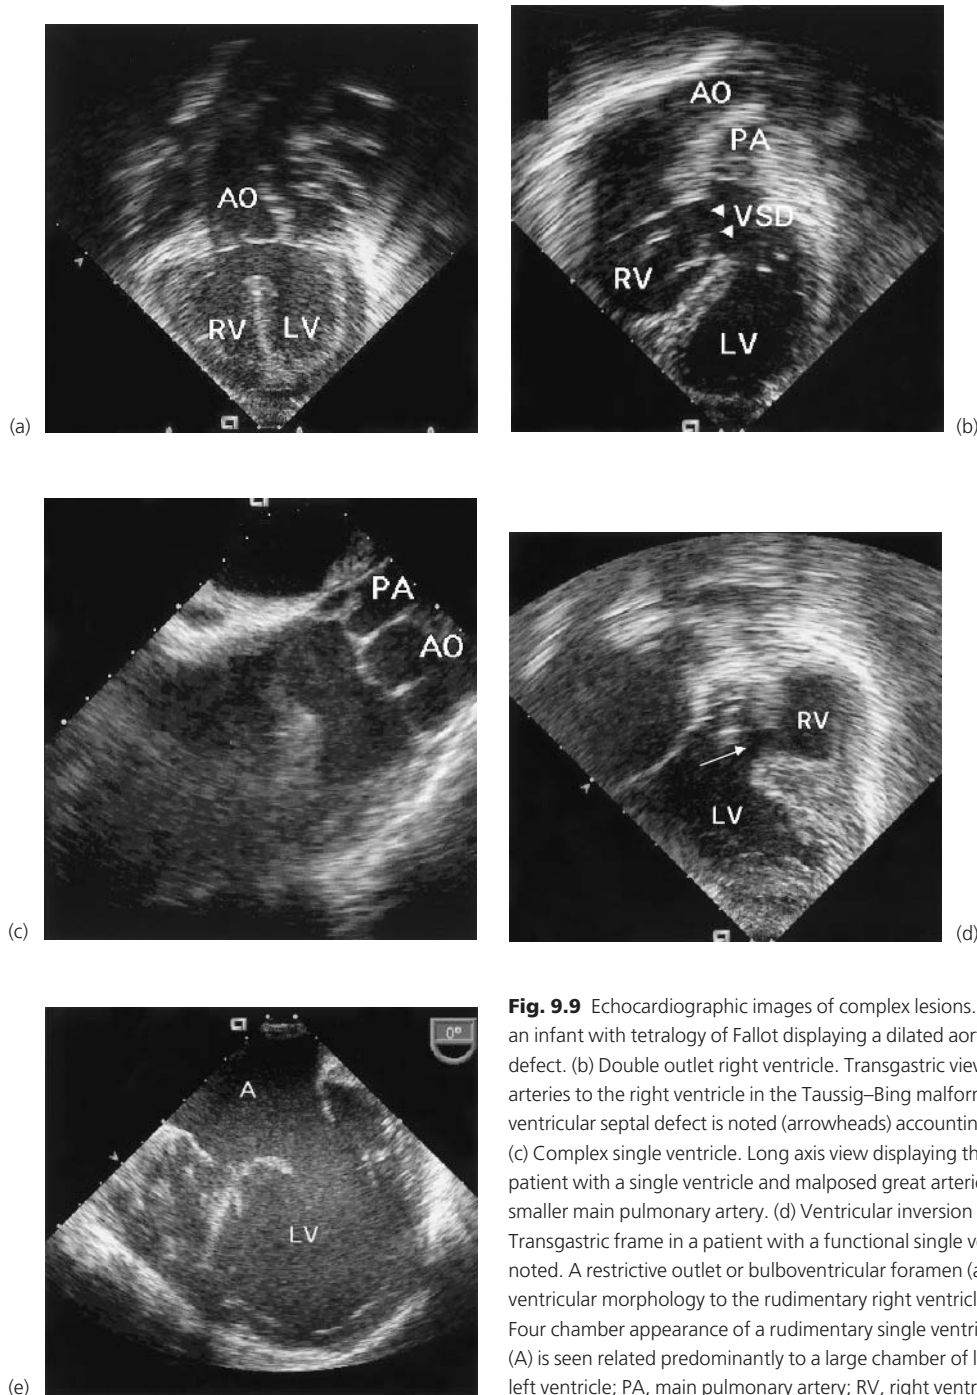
Echocardiographic images of complex lesions. (a) Tetralogy of Fallot. Transgastric view of an infant with tetralogy of Fallot displaying a dilated aortic root overriding a large ventricular septal defect. (b) Double outlet right ventricle. Transgastric view demonstrating the relationship of the great arteries to the right ventricle in the Taussig-Bing malformation. The subpulmonary location of the ventricular septal defect is noted (arrowheads) accounting for physiology similar to that of transposition. (c) Complex single ventricle. Long axis view displaying the parallel relationship of the great arteries in a patient with a single ventricle and malposed great arteries. The aorta is positioned anteriorly to the smaller main pulmonary artery. (d) Ventricular inversion (l-transposition of the great arteries). Transgastric frame in a patient with a functional single ventricle. The discrepant ventricular sizes are noted. A restrictive outlet or bulboventricular foramen (arrow) communicates the larger ventricle of left ventricular morphology to the rudimentary right ventricle or subaortic chamber. (e) Single ventricle. Four chamber appearance of a rudimentary single ventricle (univentricular heart). A common atrium (A) is seen related predominantly to a large chamber of left ventricular morphology. AO, aorta; LV, left ventricle; PA, main pulmonary artery; RV, right ventricle; VSD, ventricular septal defect.
